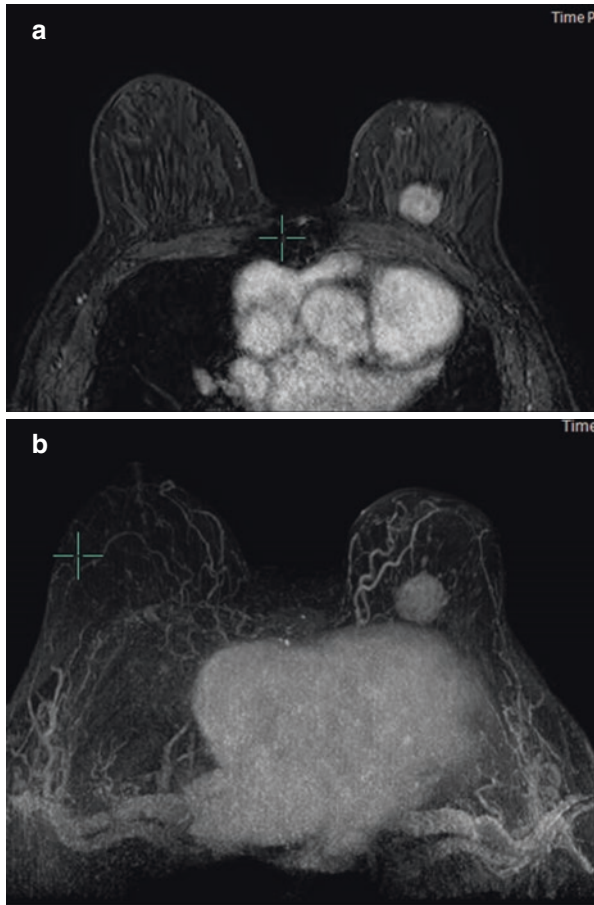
(a) Axial fat suppressed T1-weighted post-contrast breast MRI. (b) Axial post-contrast maximum intensity projection breast MRI
